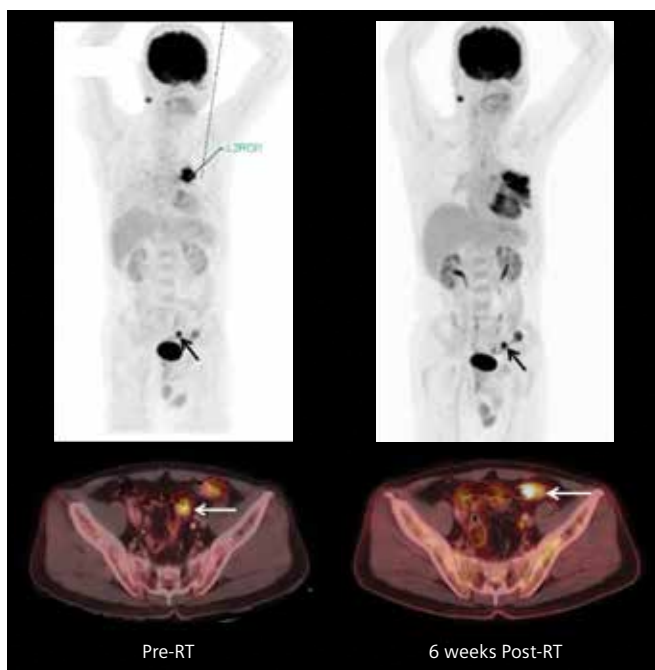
Comparison of PET maximum intensity projection (MIP) images of pre-therapy and 6 weeks post-radiation therapy PET/CT studies show a hypermetabolic primary lung tumor and the extensive radiation-induced inflammation in the tumor base and adjacent lung lobe. The PET images also show hypermetabolic focal colonic uptake in the initial study and in the follow-up study, and there is a slight increase in the degree of hypermetabolism assessed visually in the follow-up. The fused PET/CT images at the same level show a slight shift in the exact location of the affected bowel between the two studies, which is related to the extent of bowel luminal filling and bowel gas. The bowel lumen and associated hypermetabolism in the pre-therapy study was interpreted as physiological uptake since there was no clearly defined mass lesion. However, persistent hypermetabolism in the same colonic focal region with a well-defined mass lesion eroding into the lumen as defined on the follow-up PET/CT suggests a potentially malignant lesion.
